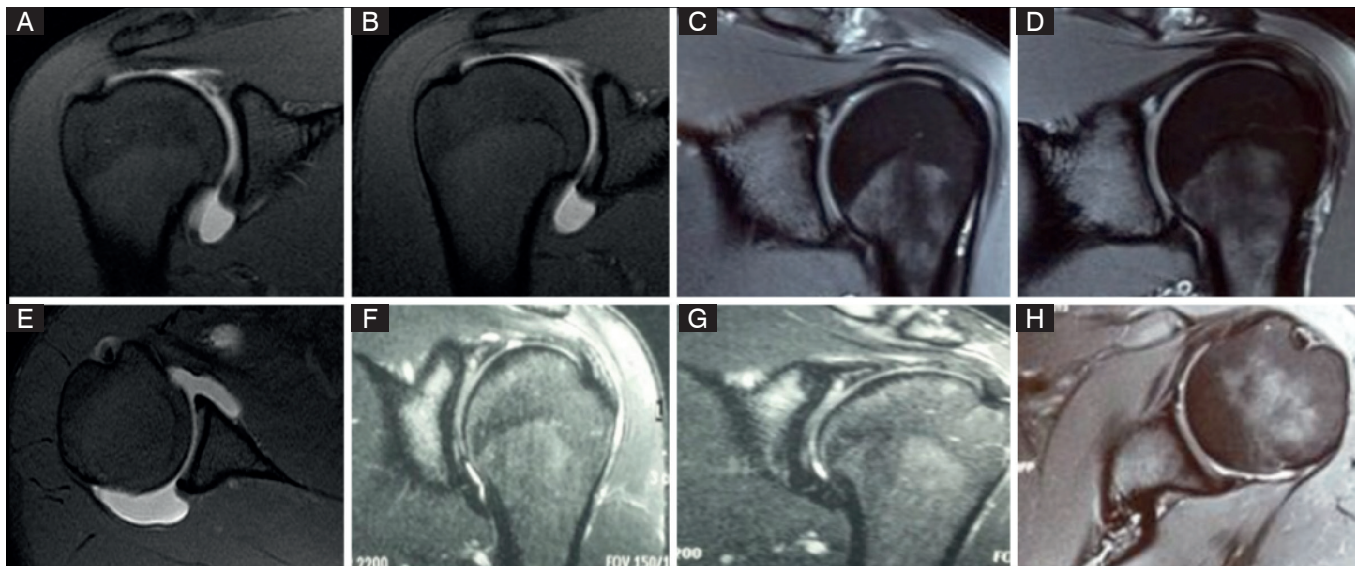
Magnetic resonance imaging (MRI) of the shoulder at T2. A, B, C, D, F e G. Coronal section of the MR showing SLAP lesion (only in arthroscopy can be concluded that it was SLAP IV). E e H. Axial cut shows tendinopathy of LHTB, without other concomitant lesions.
